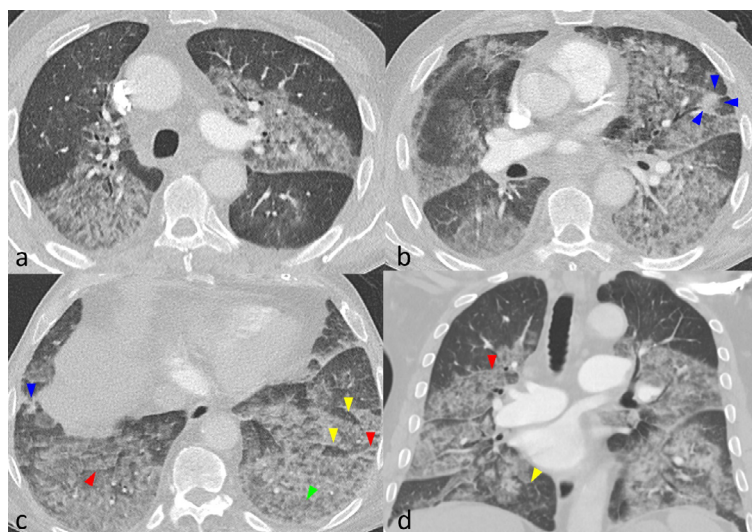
Contrast-enhanced chest CT in axial and coronal lung window reconstructions with 1.25 mm slice thickness. (a) Bilateral GGO affecting the central and subpleural lung segments. (b) Patchy consolidations in the lingual segment (blue arrowheads). (c) A geographic appearance is noted, with sparing of individual lung lobules (yellow arrowheads). Interlobular septal thickening is present bilateral (red arrowheads) with also intralobular septal thickening (green arrowheads). Patchy consolidations are also noted in the right anterobasal lower lobe segment (blue arrowhead). (d) Coronal reconstruction shows symmetrically distributed GGO with marked thickening of the interlobular septa (red arrowheads) and sparing of individual lobules (yellow arrowheads). CT = computed tomography, GGO = Ground glass opacities.
